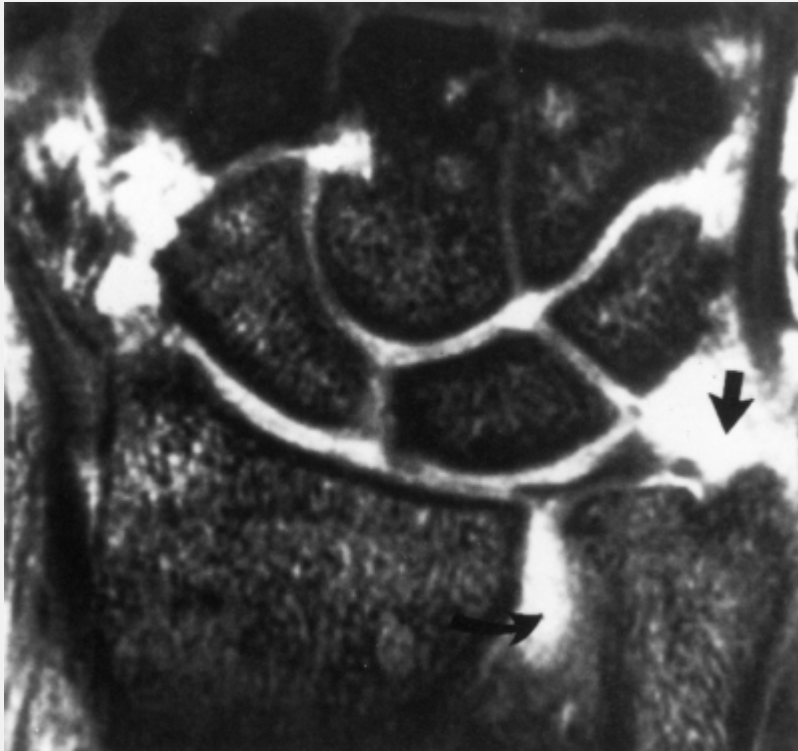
Ulnar impaction syndrome. (A) Coronal T1-weighted MR image shows a positive ulnar variance and sclerosis of the proximal ulnar aspect of the lunate (*arrow*). (B) Coronal T1-weighted MRI obtained slightly more volarly and (C) corresponding T2\*-weighted image demonstrate subchondral cysts (straight arrows) and involvement of triquetrum (*curved arrows*). Note also disruption of the triangular fibrocartilage.
